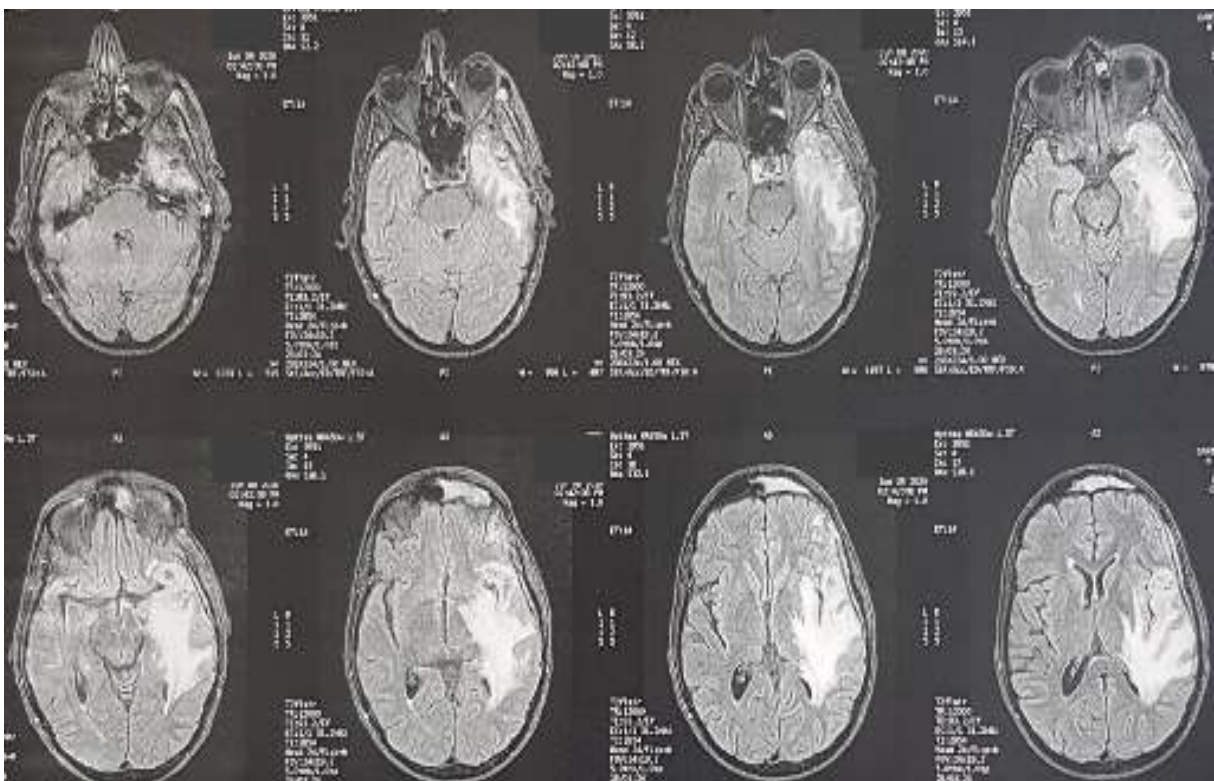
MRI FLAIR control of the follow up at 10 months of the patient previously diagnosed for left temporal lobe glioblastoma and treated by subtotal resection followed by radiotherapy and chemotherapy, presenting a worsening course of headaches without neurological deficit. We find out a severe edema involving the adjacent white matter tracts.
